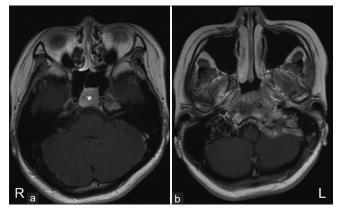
Preoperative magnetic resonance imaging findings. Contrast-enhanced T1-weighted image showed the sphenoid sinus lesion with homogenous enhancement (*) (a). The tumor involved several skull base structures and extend into posterior fossa (b).
